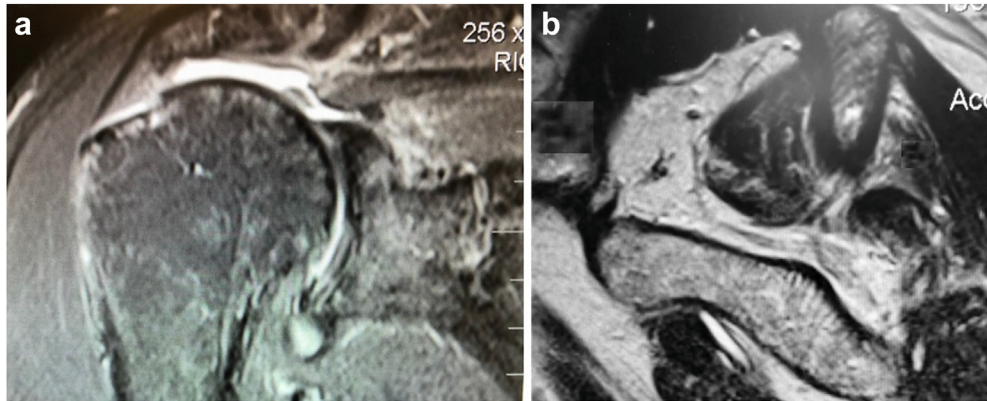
(a) Preoperative coronal T2 and (b) sagittal T1 magnetic resonance imaging (MRI) showing four-centimeter retracted rotator cuff tear and Goutallier stage II supraspinatus.
